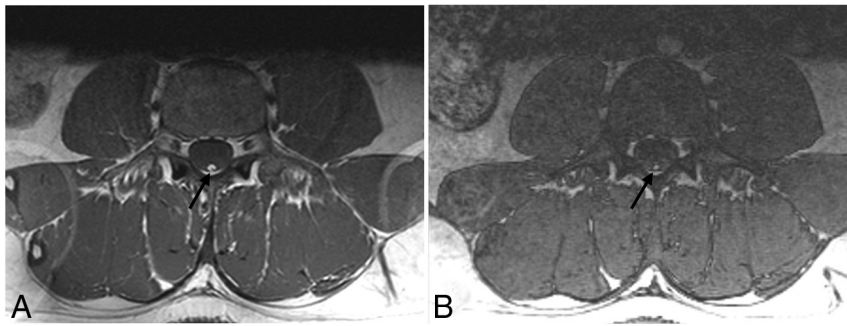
Different acquisitions of T1-weighted MR imaging on the axial planes of the lumbar region at the level of the L4–L5 intervertebral disc in an 18-year-old patient. A, T1 FSE sequence shows the dark-signal thecal sac containing the barely visible hypo- to iso-signal intensity cauda equina nerve roots and a round midline intradural lesion (black arrow) with bright signal intensity located posteriorly in the spinal canal at the expected anatomic site of the filum terminale, consistent with a FIL. Phase wrap-around artifacts are noted on both sides of the image. B, A radiofrequency spoiled 3D gradient-echo sequence known as VIBE of the same patient study at the same level shows a similar bright-signal intradural structure (black arrow), the FIL. Note the smaller AP and RL dimensions of the FIL compared with the T1 FSE sequence (A). VIBE/LAVA can underrate the AP and RL diameters of the FILs.
